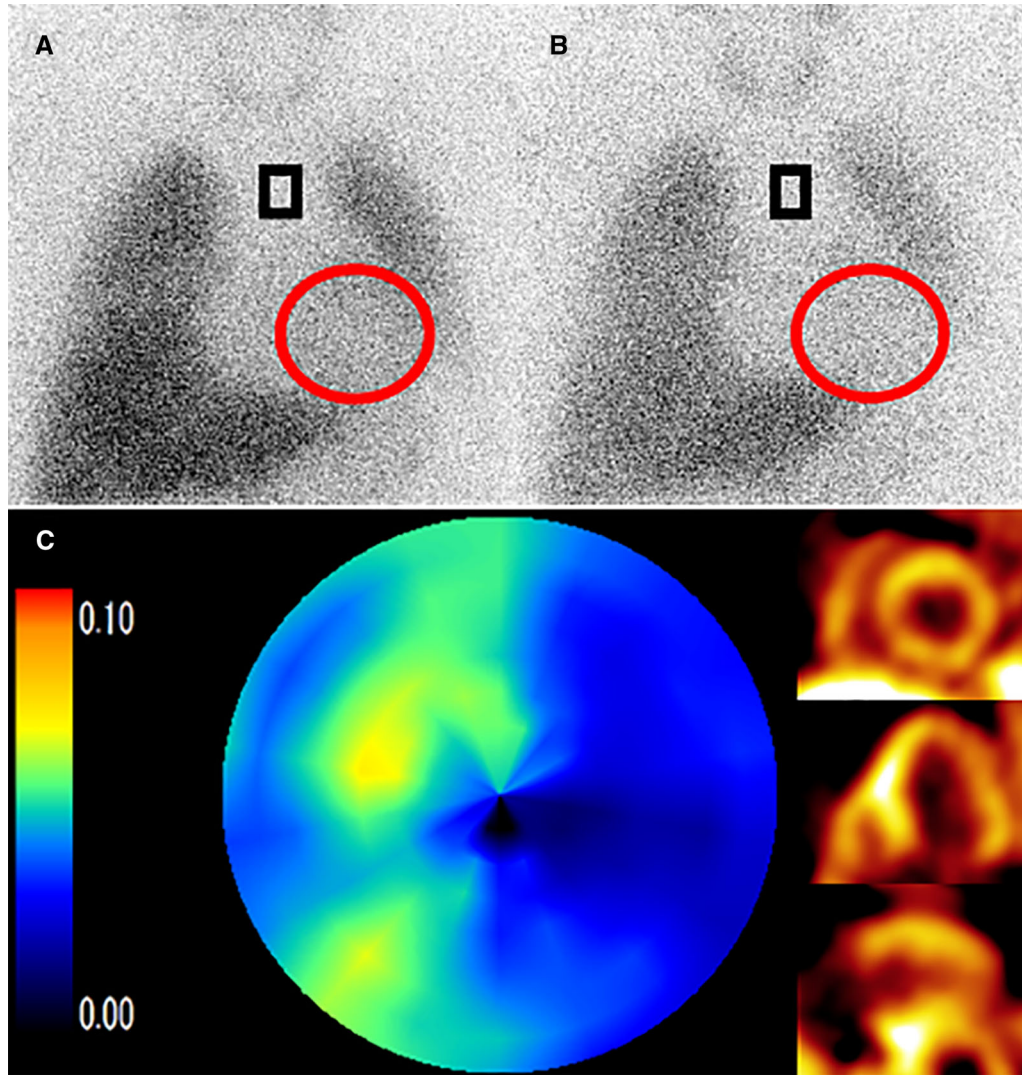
Representative case of ^{123}I -MIBG scintigraphy and ^{11}C -hydroxyephedrine PET. A male in his 40s suffered from dilated cardiomyopathy, with a left ventricular ejection fraction of approximately 30%. An early anterior planar image at 15 min after injection (A) and a late anterior planar image starting at 4 hours after injection (B) are acquired to calculate the heart-to-mediastinum ratio (HMR) and the washout ratio. Calculated early HMR, delayed HMR, and washout ratio were 1.7, 1.4, and 40.3%, respectively. Whole retention index from ^{11}C -hydroxyephedrine PET was calculated as 0.044. Distribution of sympathetic nerve system was lower especially in the lateral wall.
